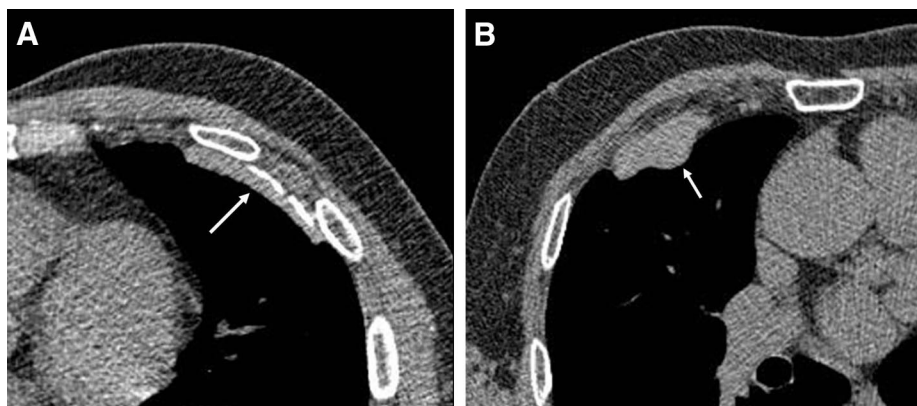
A, low-dose computed tomography (LDCT) images from different study participants. Post prior asbestos exposure, evidence of flat, partly calcified pleural plaques along the costal pleural surface (arrow). B, Post prior asbestos exposure, evidence of lobulated pleural plaques along the costal pleural surface, without calcifications (arrow).
